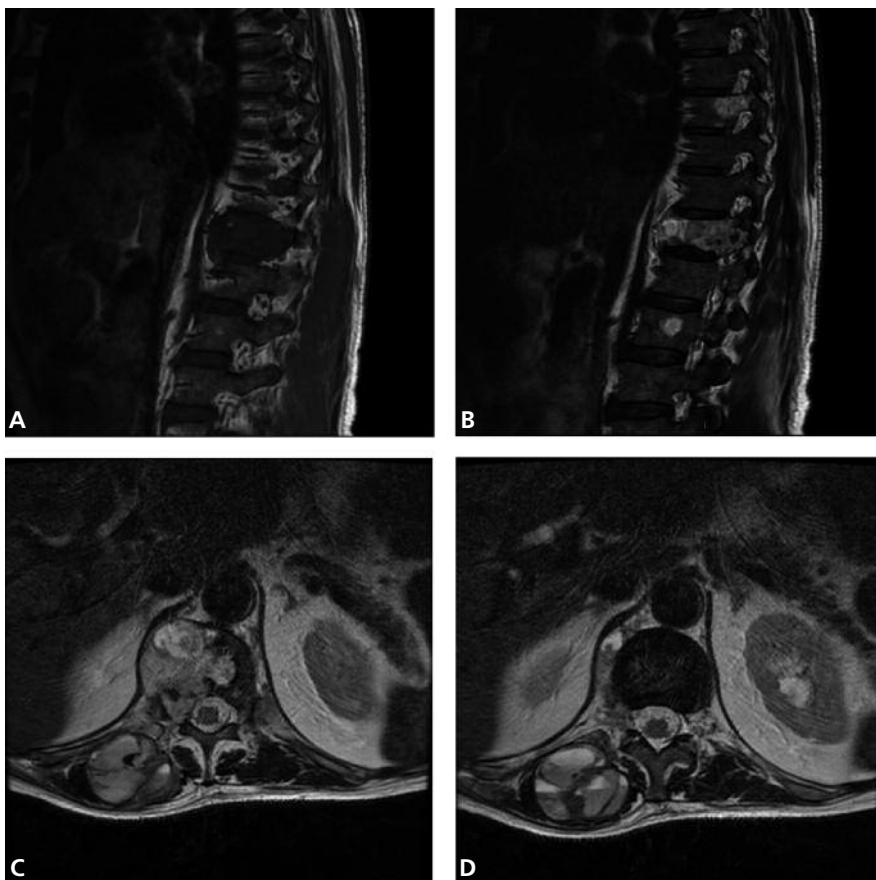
A, A sagittal magnetic resonance image of the dorsal spine showed hypointense signal lesion on T1-weighted and B, an hyperintense signal lesion on T2-weighted magnetic resonance image involving the right part of the eleventh vertebral body and the right vertebral pedicle. C-D, A transverse T2-weighted magnetic resonance image shows a fluid-filled lesion of 3x4x10 cm in the context of the right paravertebral muscles.
